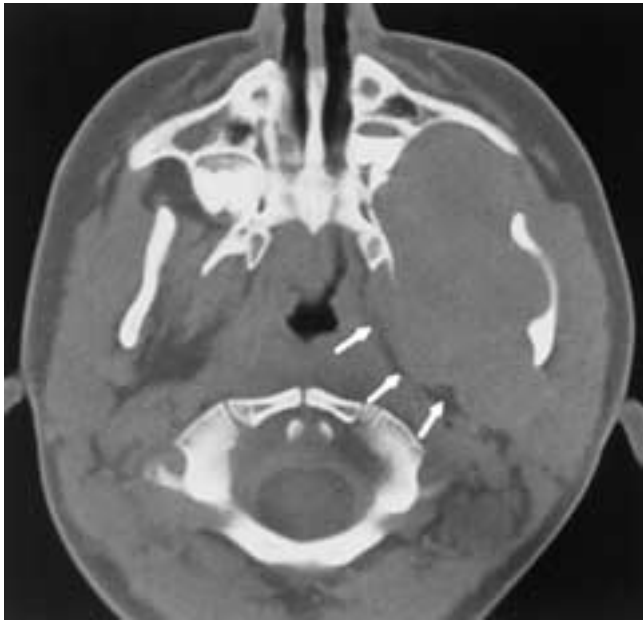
Axial CT scan shows a masticator space mass in a 6-year-old patient with aggressive fibromatosis of the masticator space with deviation of the left mandible and left maxillary sinuses. This mass compresses the parapharyngeal space posteriorly and medially (*arrows*). This deviation is typical of masticator space masses.
